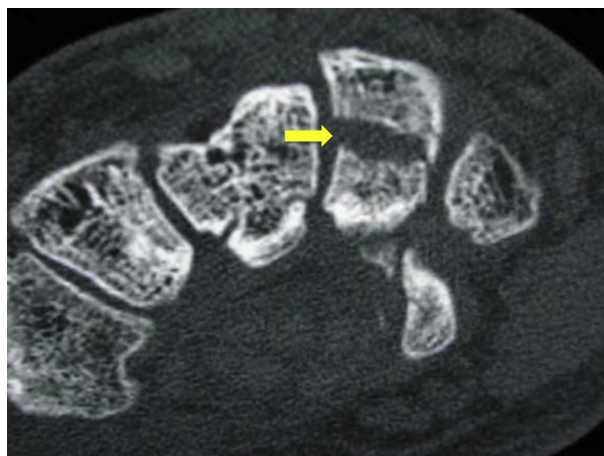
Computed tomography scan of a comminuted hamate fracture (arrow).
